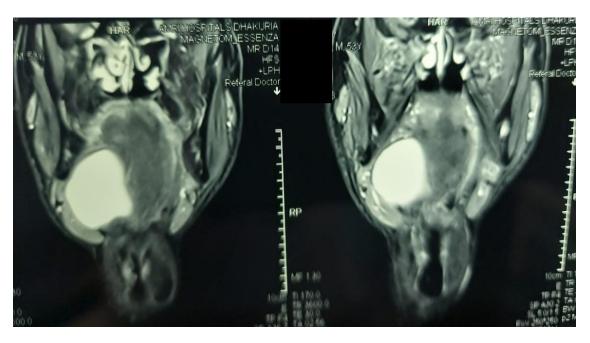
MRI showing the submandibular swelling (Coronal view)
